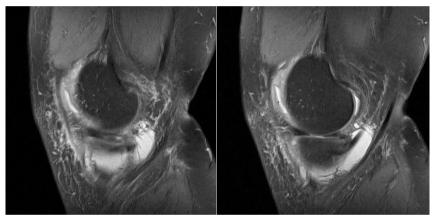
A-B): Knee MRI (March, 2016).
